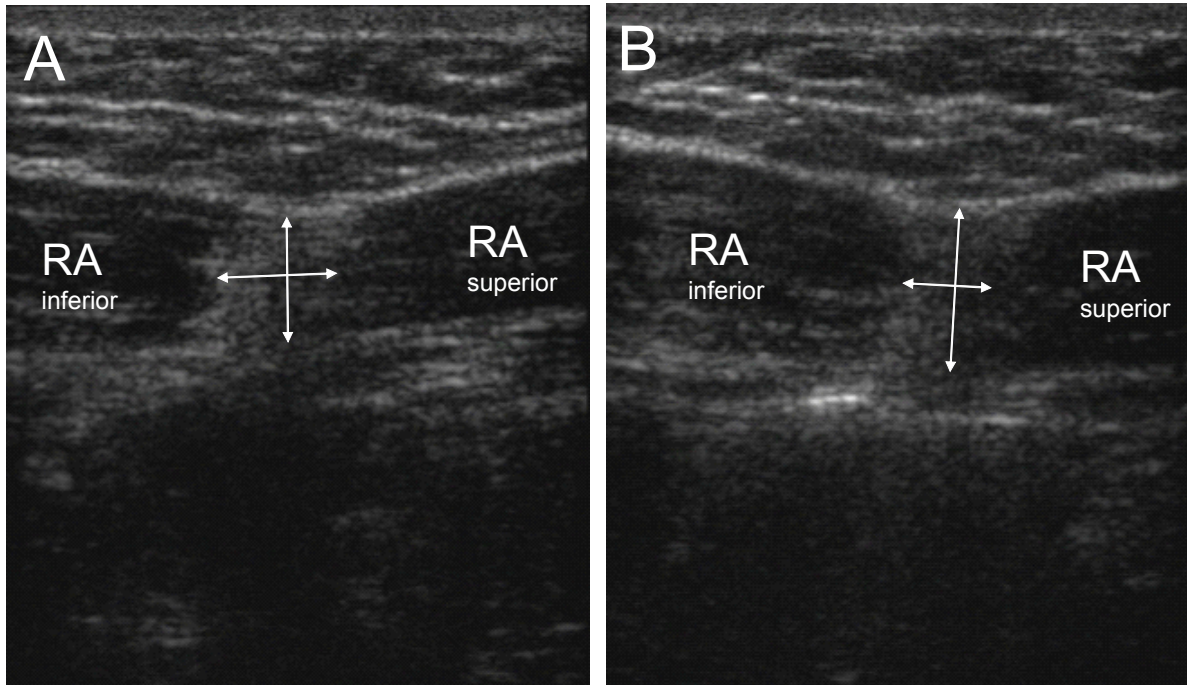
Example of an ultrasound image, taken sagittally through the abdomen, of the RA tendinous intersection captured at relaxation (A) and 50% of maximum contraction (B). The portion of the image above the RA is subcutaneous tissue and skin, while below the RA is visceral content. The more vertically oriented arrows indicate the measure of tendon thickness; the more horizontally oriented arrows indicate the measure of tendon length.
